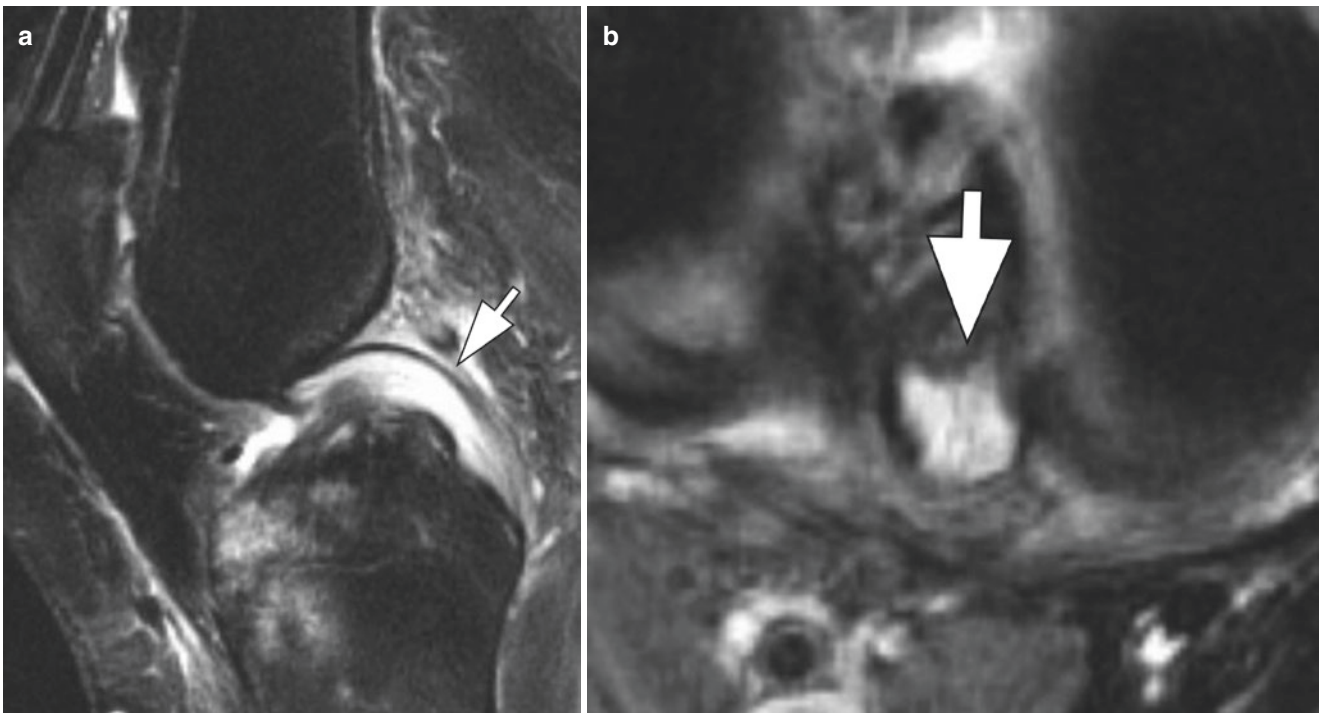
PCL muroid degeneration. (a) Sagittal and (b) axial T2-weighted images. There is increased signal within the PCL and a peripheral rim of intact fibers – “tram-trak” appearance (arrows)
